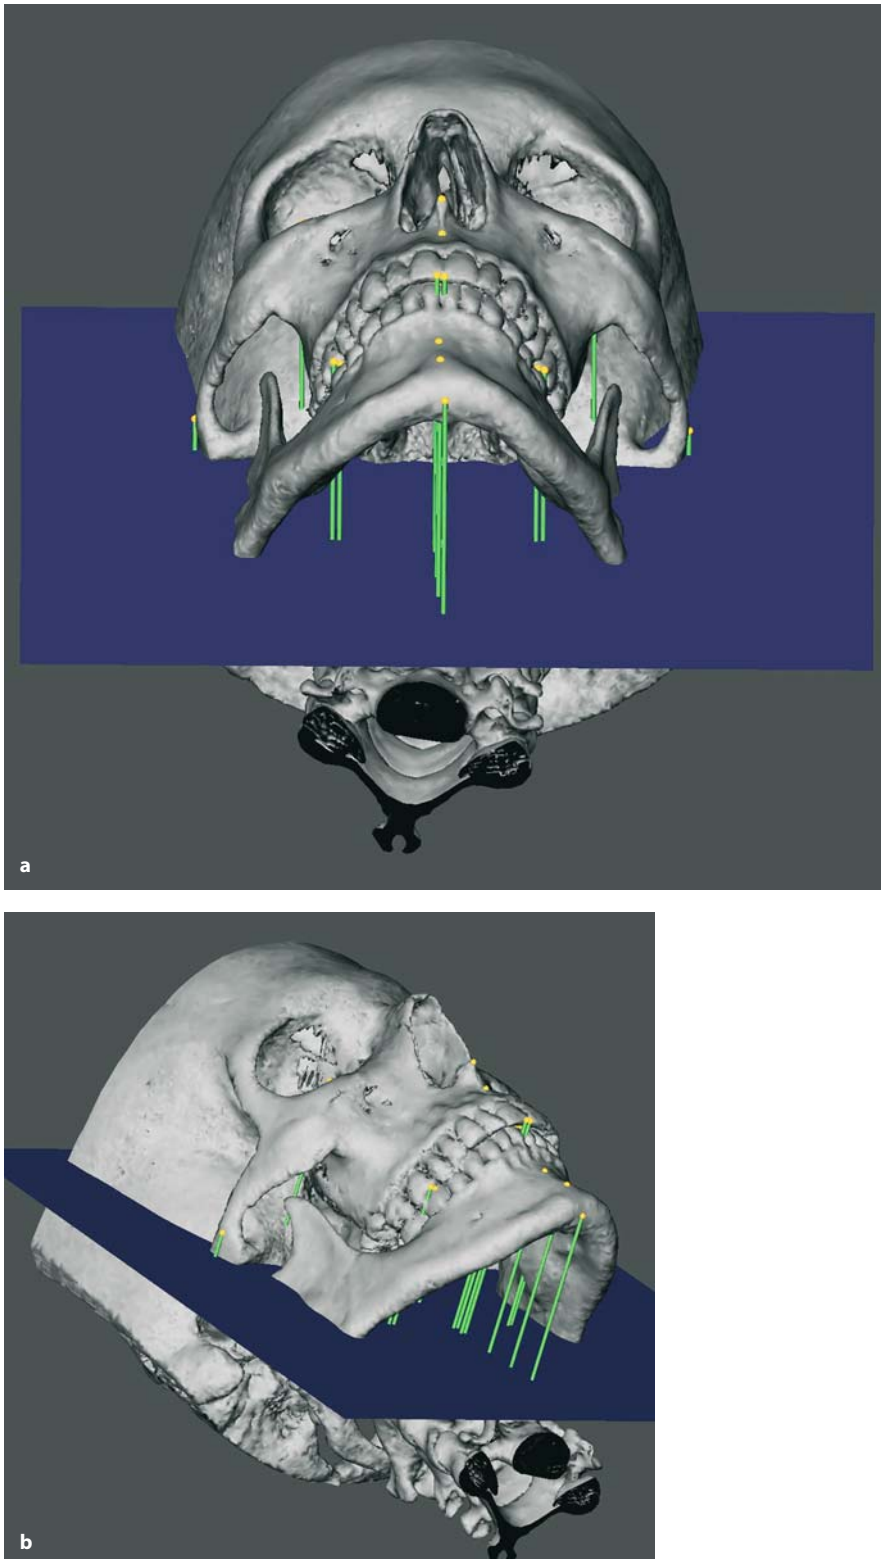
a, b. Set-up of horizontal orthogonal hard tissue measurements to the vertical (y) plane (3-D CT, patient K.C.)
